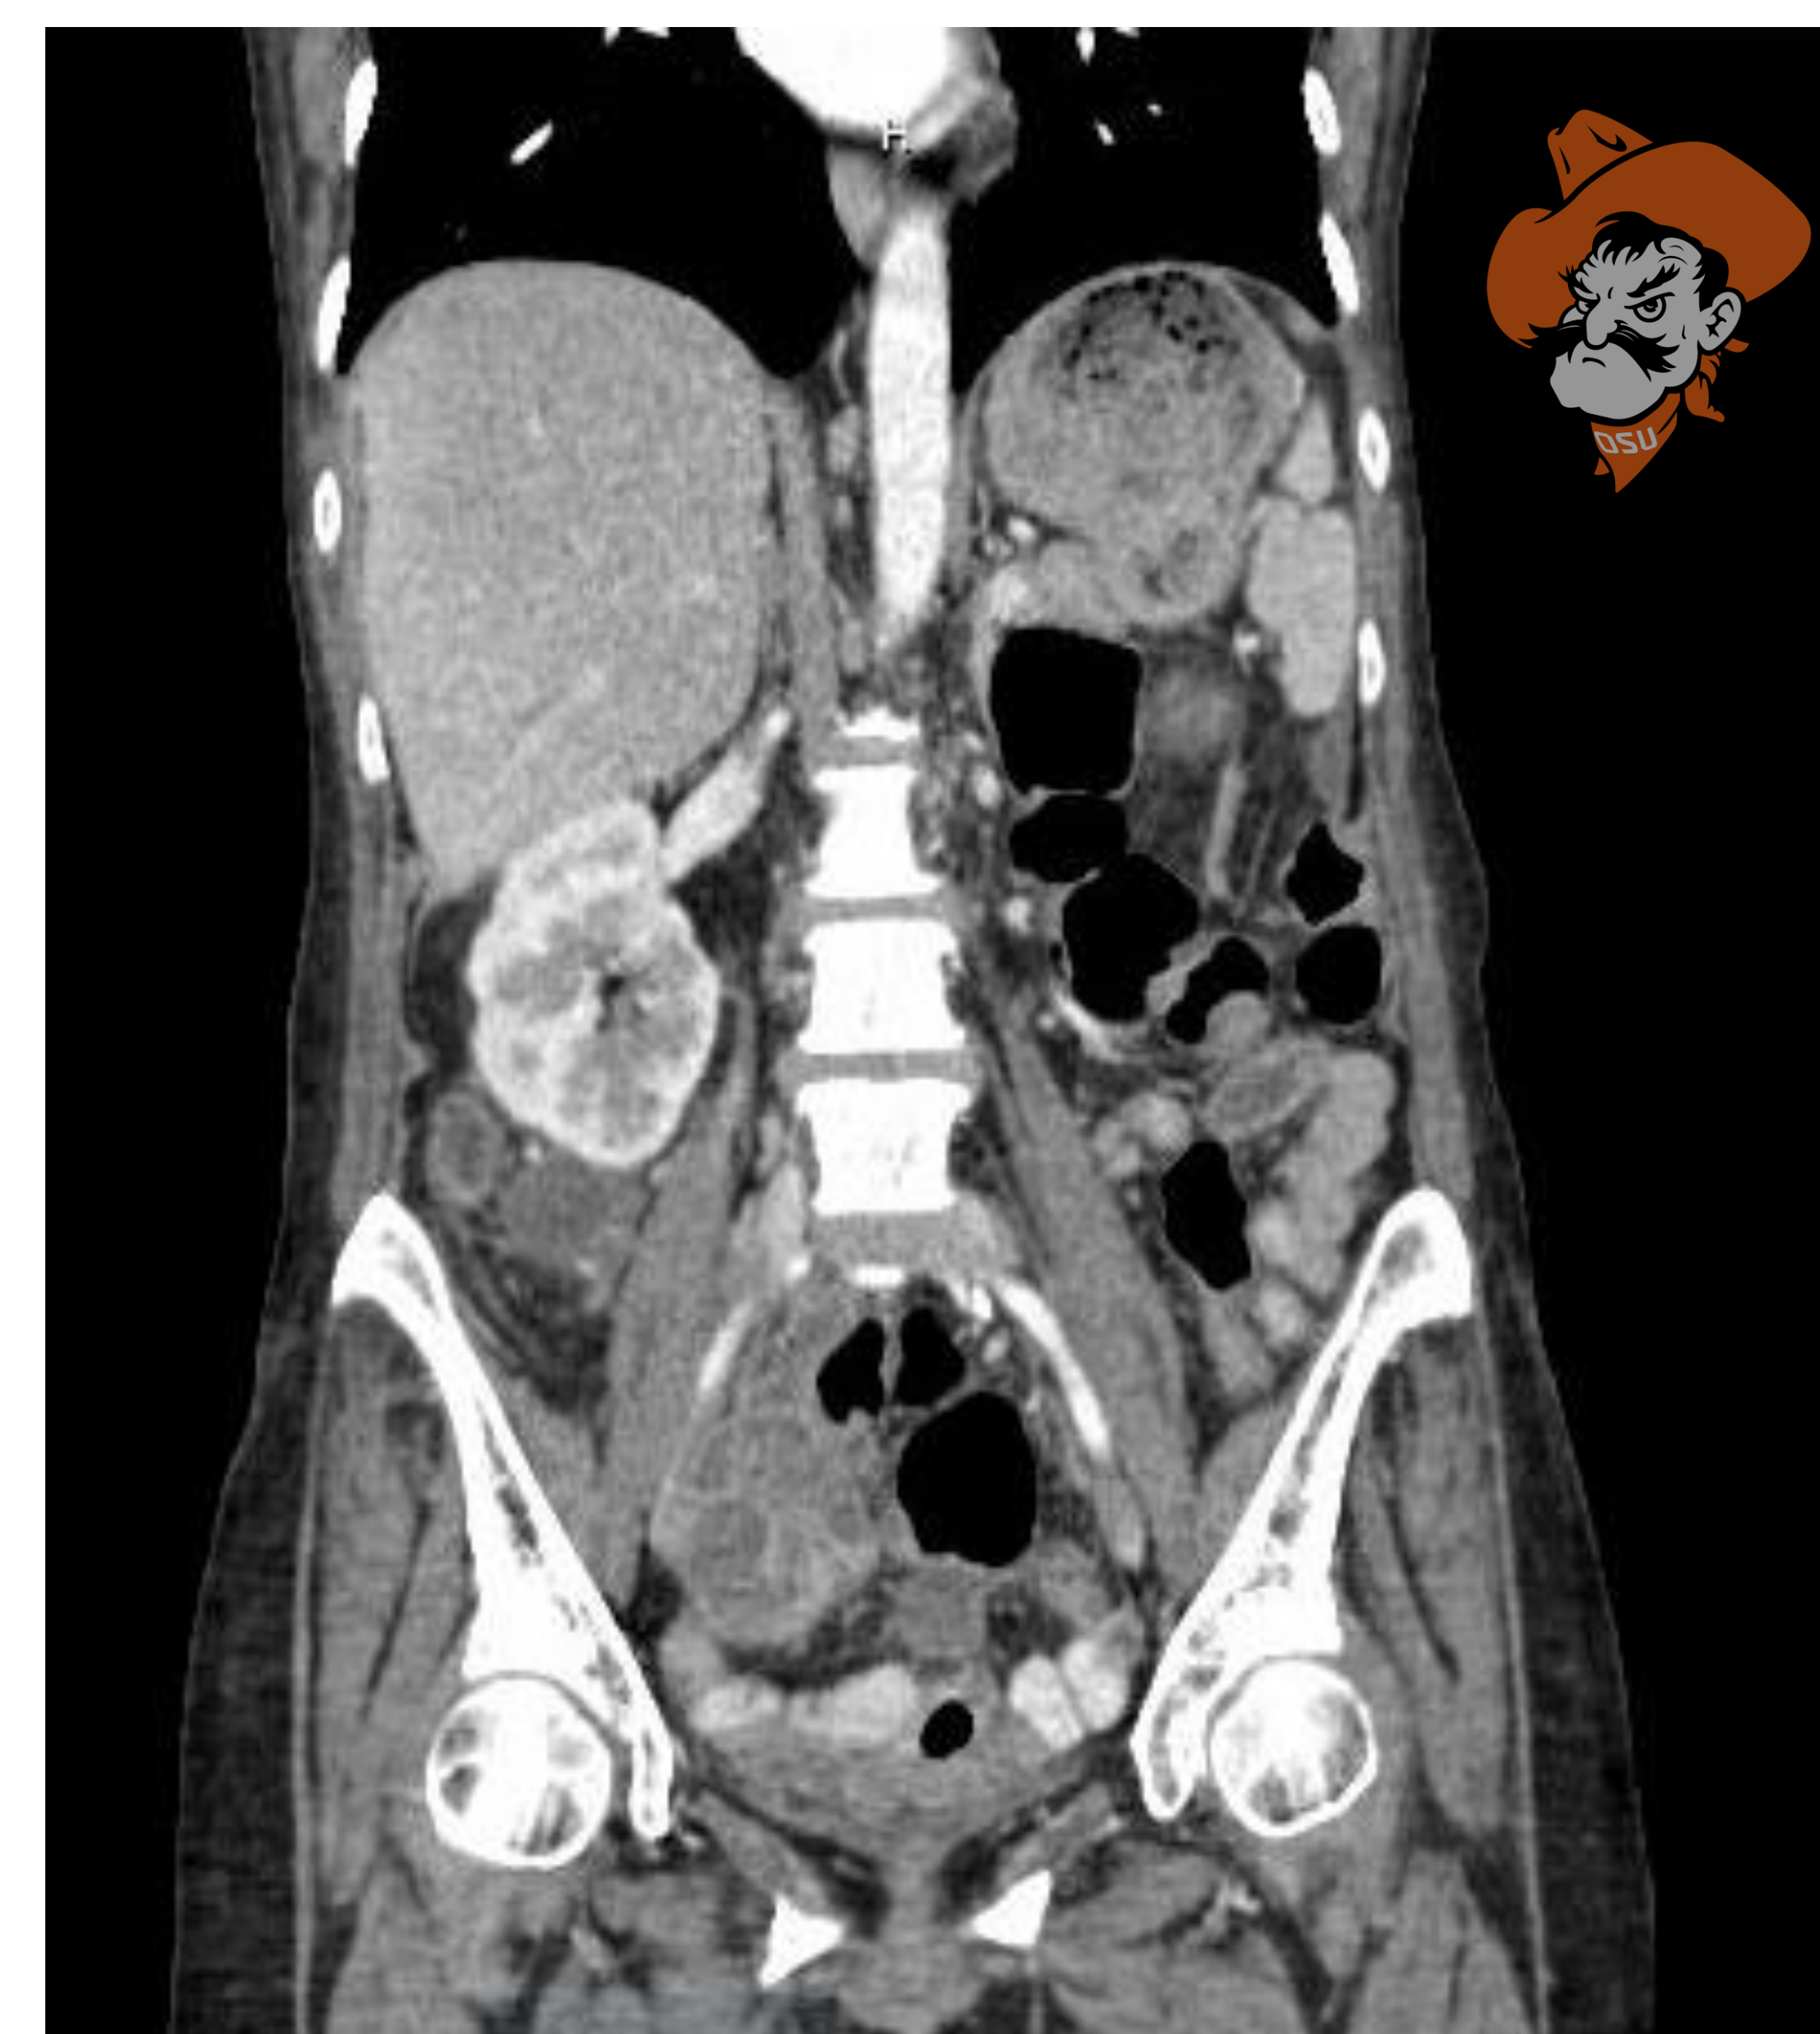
CT Abdomen/Pelvis- Diffuse multifocal loculated pockets of ascites throughout the abdominal cavity, with a multiseptated cystic right adnexal mass, concerning for metastatic ovarian carcinoma.
